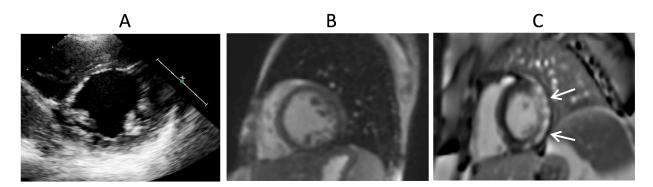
Three short axis images of the same patient with Duchenne muscular dystrophy. A) Echocardiographic image of mid-papillary short axis which is unable to show LGE but would be adequate for STE measures. B) CMR short axis steady state free processing image without contrast which cannot show LGE but is able to be used for FT strain measures. C) CMR short axis imaging post gadolinium contrast administration showing LGE (bright white) in the posterior and lateral segments (arrows).
